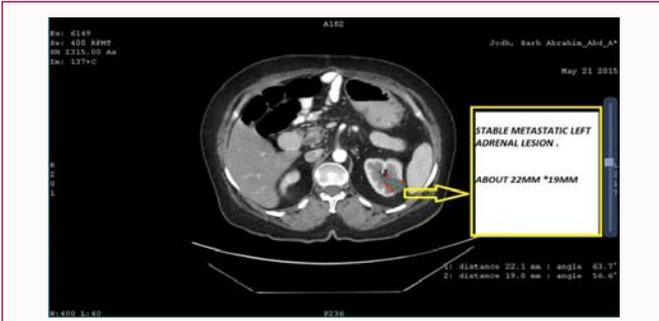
CAP-CT scan was revealed left adrenal mass lesion (2.2*1.9 cm) on May/2015.
